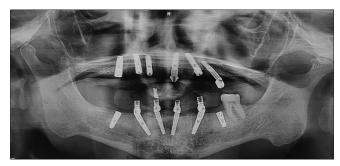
Orthopantomogram showing screw retained provisional restorations
